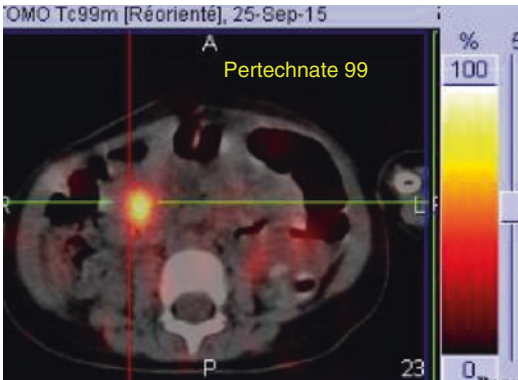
Chronic abdominal pain secondary to MD ulceration in a 4-year-old girl. Tc-99m pertechnetate scintigraphy: A hyperintense activity is identified on the right iliac fossa corresponding to gastric mucosa uptake. (Courtesy G Petyt, MD)
